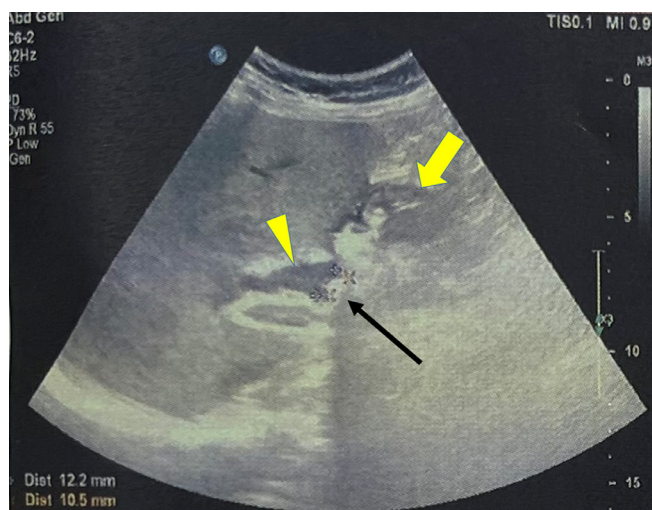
Abdominal ultrasound shows contracted gallbladder with apparent wall thickening (yellow arrow) and dilated common hepatic duct (yellow arrow head). A hyperechoic lesion with posterior acoustic shadowing at the common hepatic duct area (black arrow) suggested choledocholithiasis.
